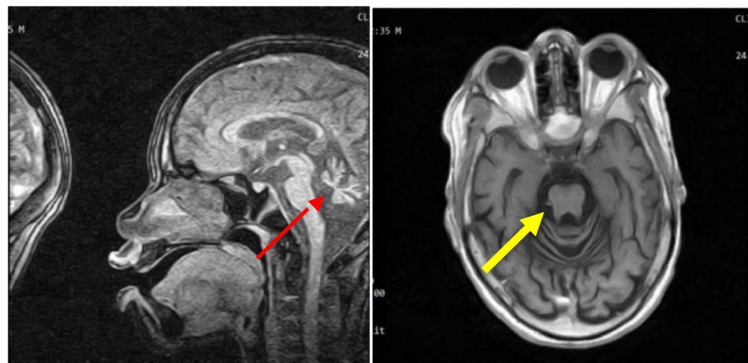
Brain MRI: Cerebellar cerebral atrophy (red arrow). Molar tooth sign (yellow arrow).
